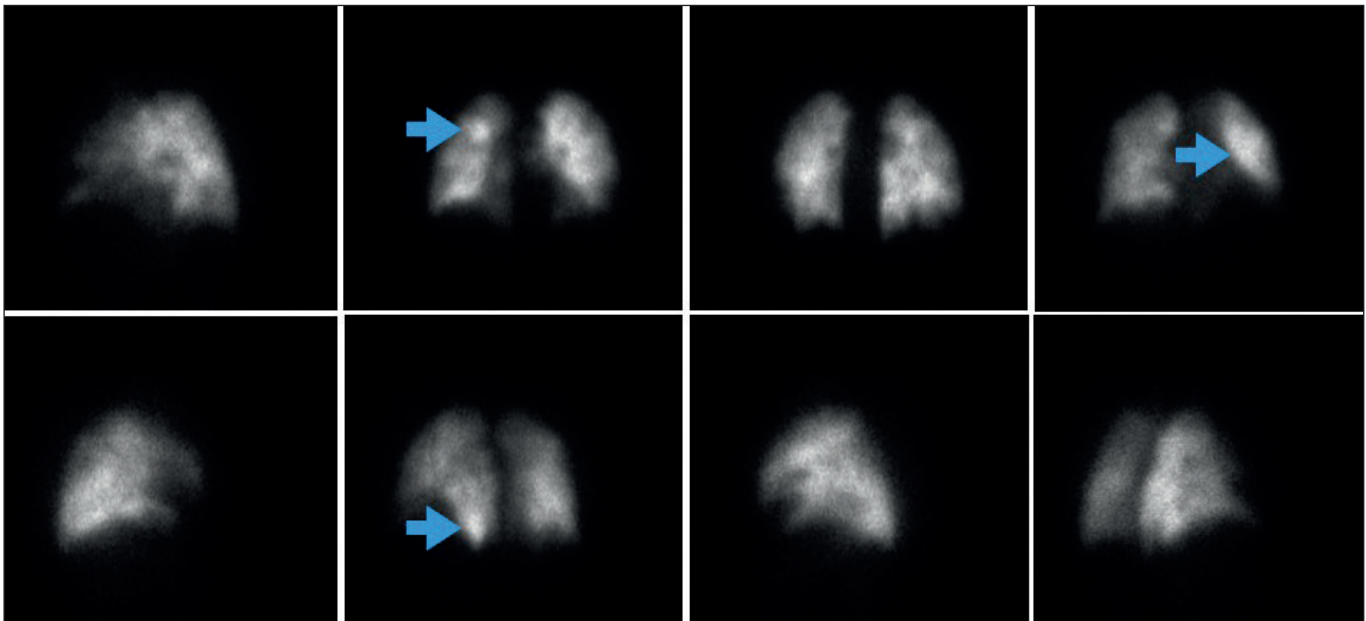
A patient with an abnormal signaling observed on pulmonary scintigraphy. The patient has perfusion defects in both basal and apical segments bilaterally.
